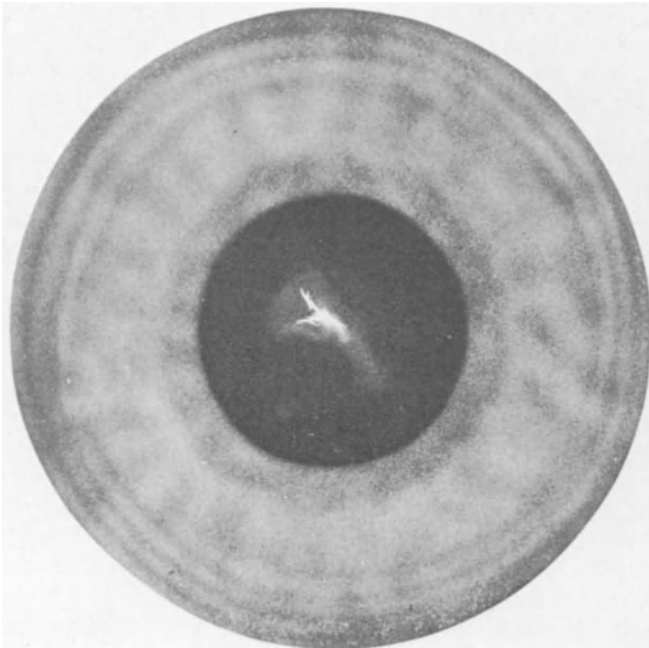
Beware the full-thickness corneal scar. When in doubt, x-ray.
